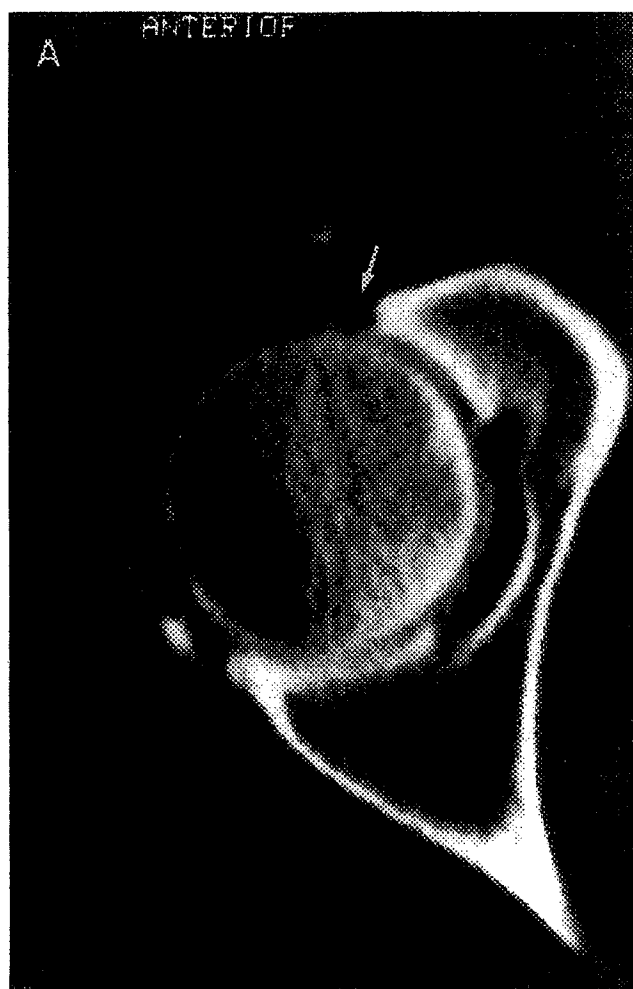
A 42-year-old man with chronic anterior right hip pain following a twisting injury. (A) Arthro-CT scan shows tearing of the anterior labrum, identified by the presence of contrast within the substance of the labrum [Arrow]. (B) Arthroscopic view of the right hip from the anterolateral portal showing a chronic tear [Arrow] of the anterior labrum.
